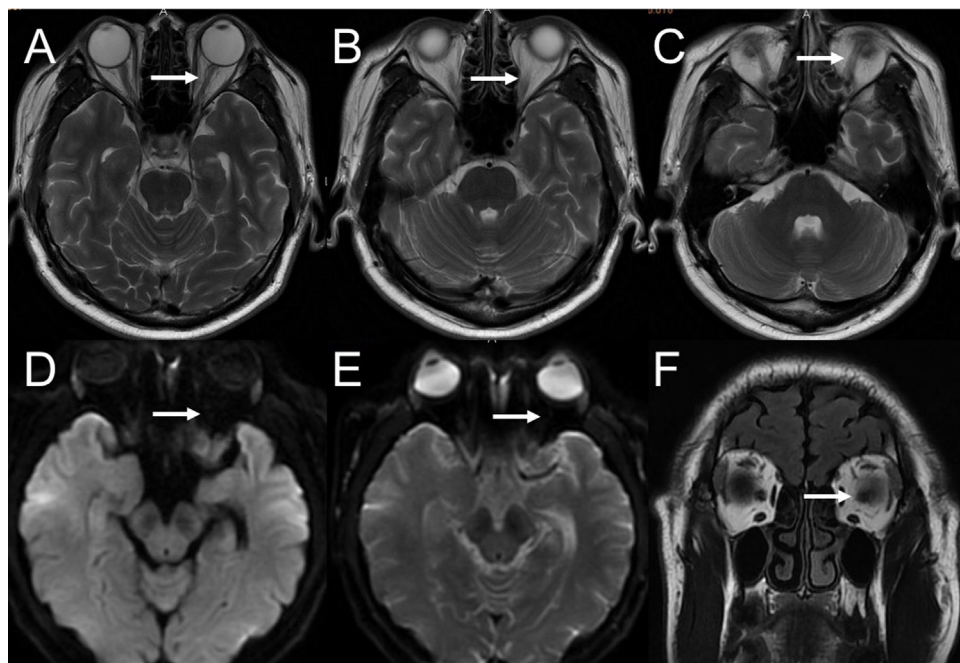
Brain MRI in March 2016 showing that the optic nerve hyperintense T₂ and DWI lesions had resolved.
